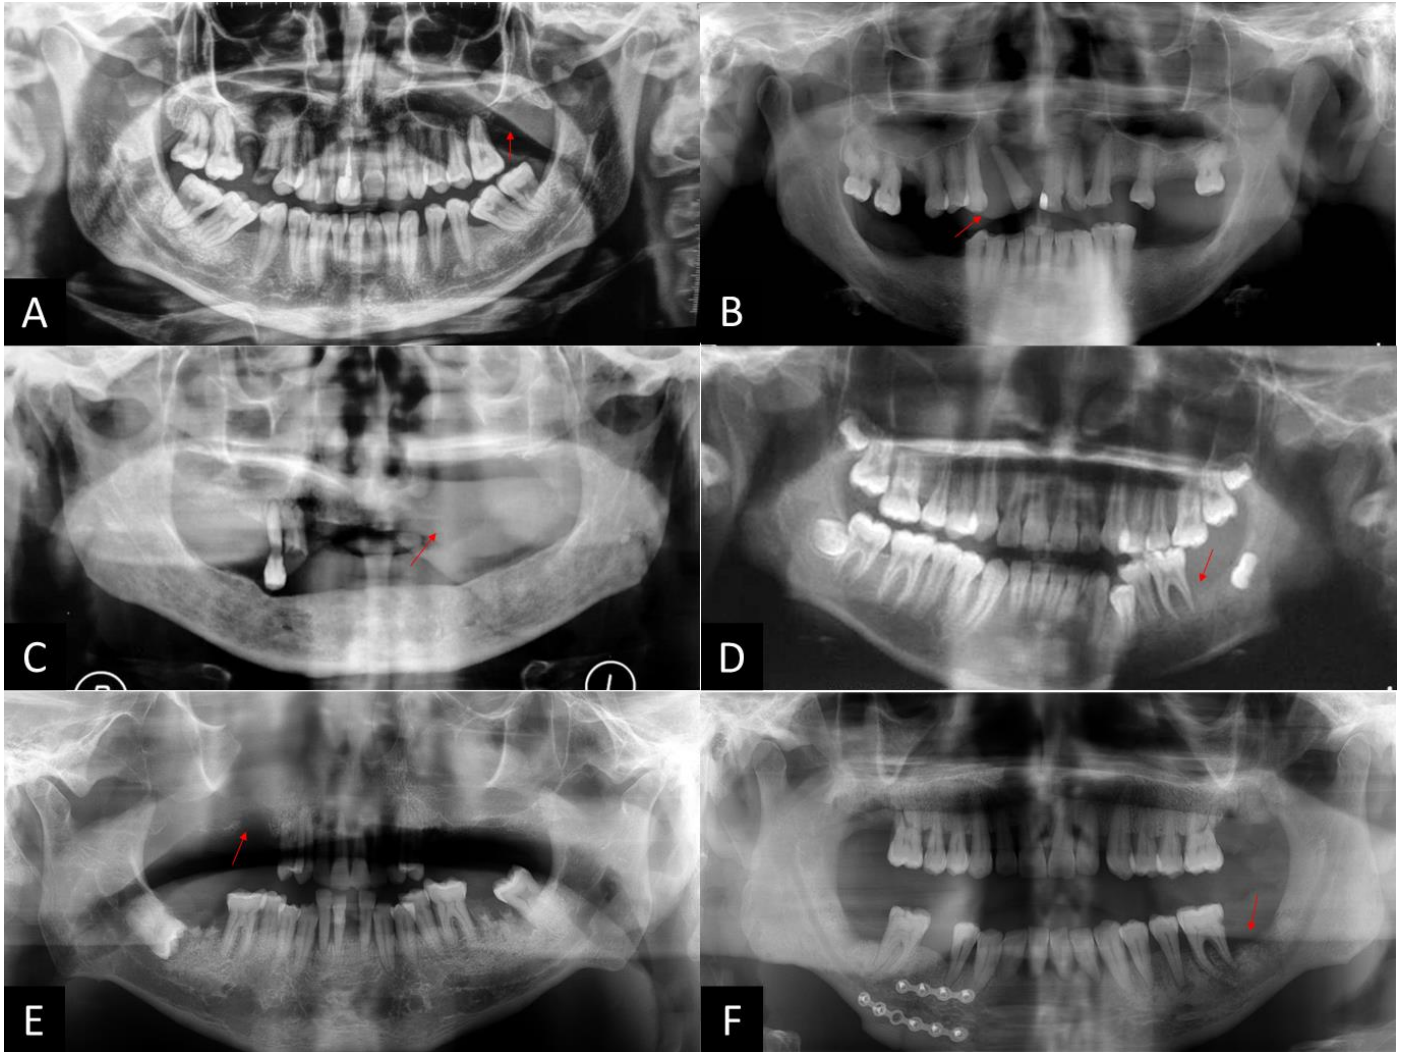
Radiographic findings of lymphomas affecting the jaws observed in panoramic images. A) Case diagnosed as plasmablastic lymphoma with a radiolucent destruction in the posterior region, left side of the maxilla (red arrow). B) Case diagnosed as DLBCL, NOS affecting the maxilla leading to a floating tooth aspect of the tooth 12 (red arrow). C) Case diagnosed as DLBCL, NOS with radiolucency and destruction of the anterior and posterior left edentulous maxilla, with radiopacity in the left maxillary sinus (red arrow). D) Case diagnosed as a Burkitt lymphoma with a radiolucent ill-defined destruction of the alveolar bone in the left side of the mandible leading to a floating tooth aspect (red arrow). E) Case diagnosed as plasmablastic lymphoma affecting the posterior right maxilla (red arrow), resulting in encroachment and opacification of the right maxillary sinus and destruction of the orbital floor and lateral nasal border. F) Case diagnosed as plasmablastic lymphoma affecting the left side
